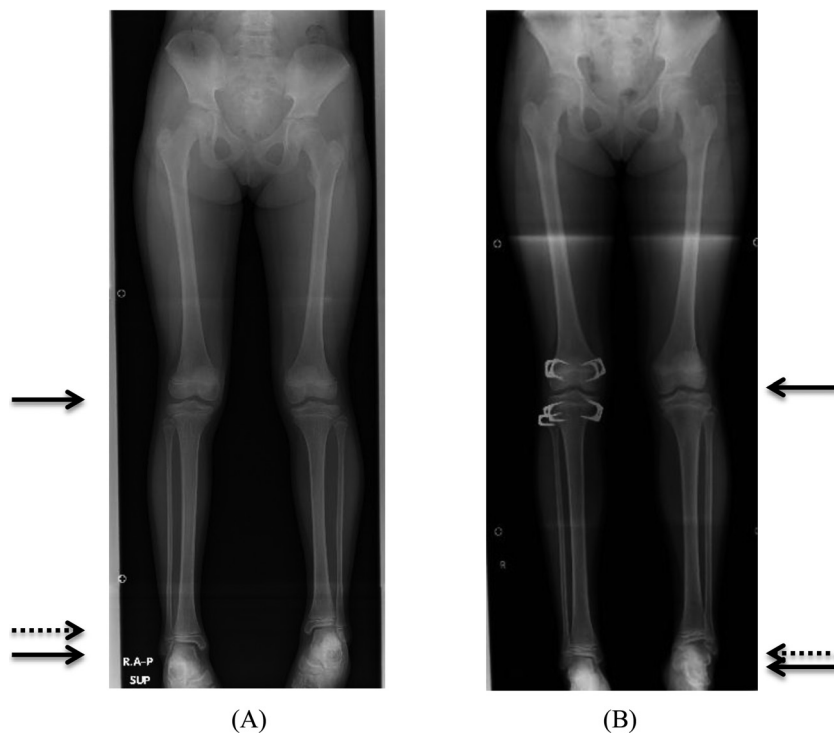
Radiography of the lower limbs of the patient. (A) The radiographs show that the left leg is shorter than the right leg. (B) Six months after the operation, the LLD has not yet decreased.
